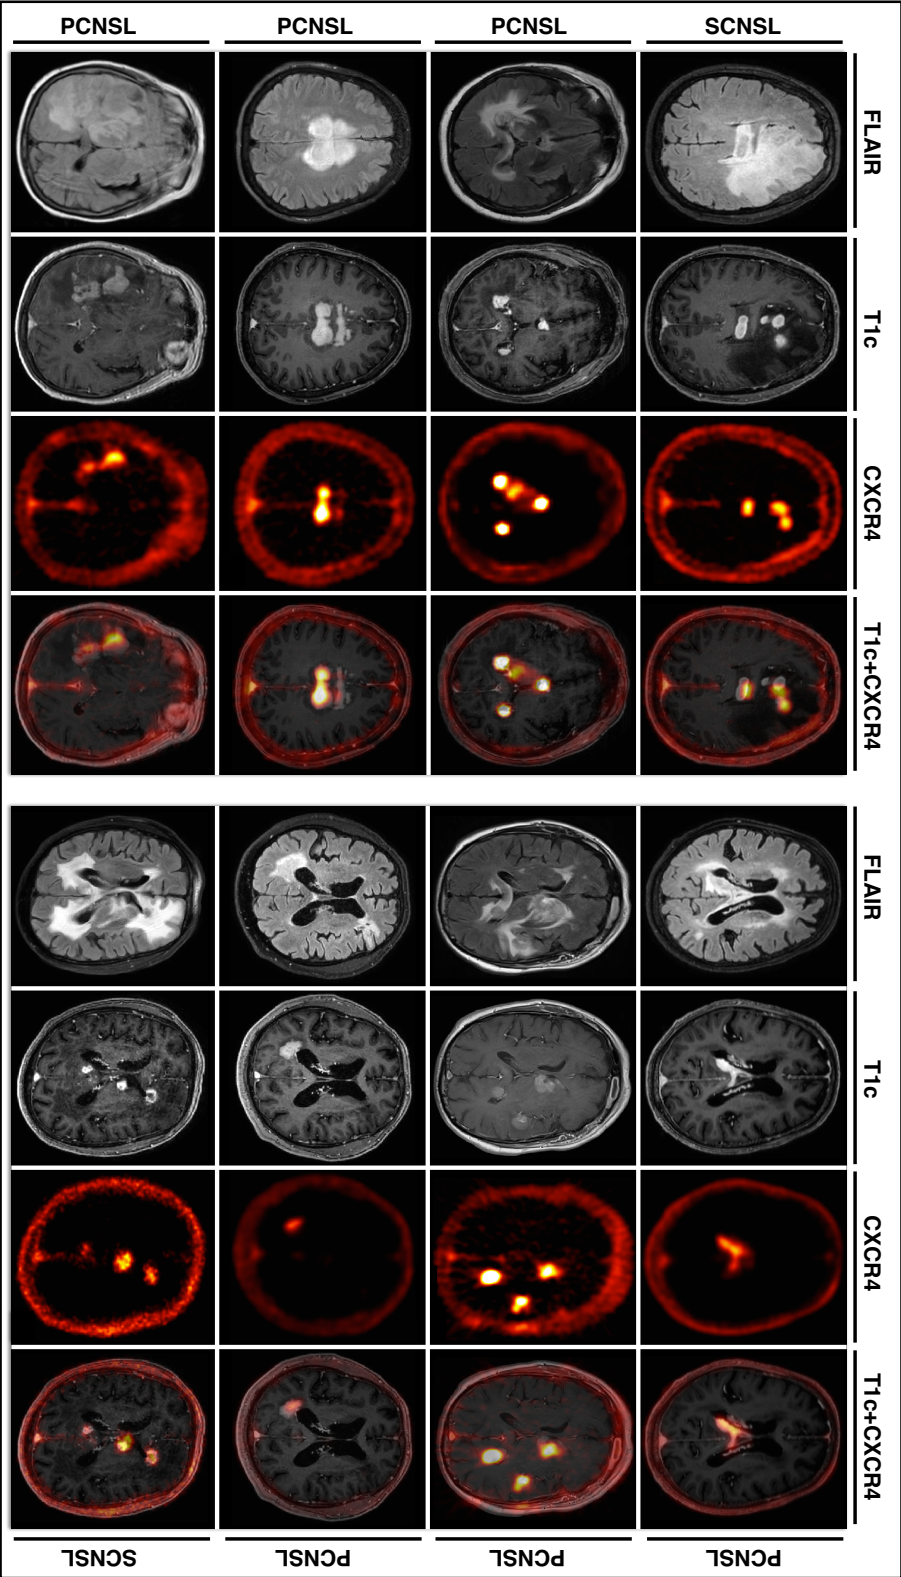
Specificity of the CXCR4-directed PET imaging for CNSLs. Shown are pre-treatment scans of 8 patients diagnosed with either PCNSL or SCNSL. The CXCR4-PET is visually positive in all 8 patients and correlates well with the lymphoma lesions determined by the T1c MRI.
